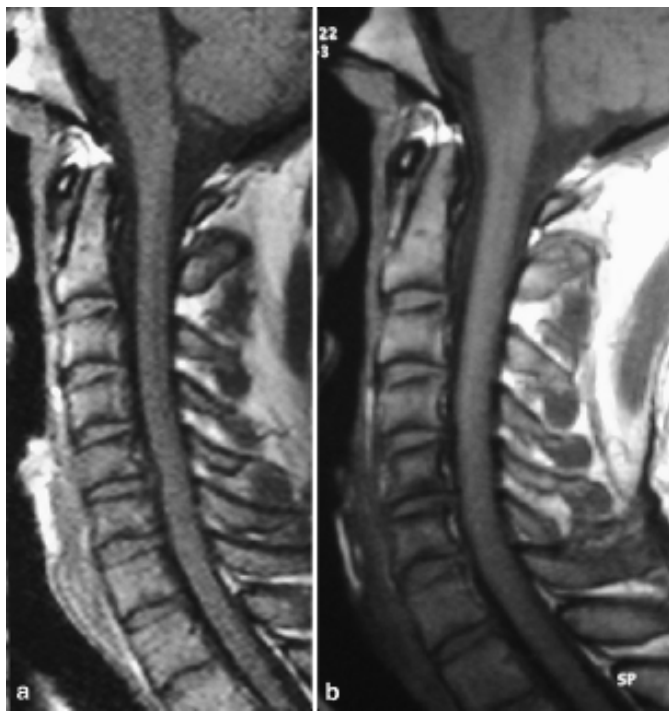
a T<sub>2</sub>-weighted sagittal MRI showing C6–7 extruded disc herniation. b T<sub>2</sub>-weighted sagittal MRI showing spontaneous regression of the C6–7 extruded disc herniation. c T<sub>2</sub>-weighted axial MRI showing C6–7 posterocentral extruded disc herniation. d T<sub>2</sub>-weighted axial MRI showing spontaneous regression of the C6–7 posterocentral extruded disc herniation.
